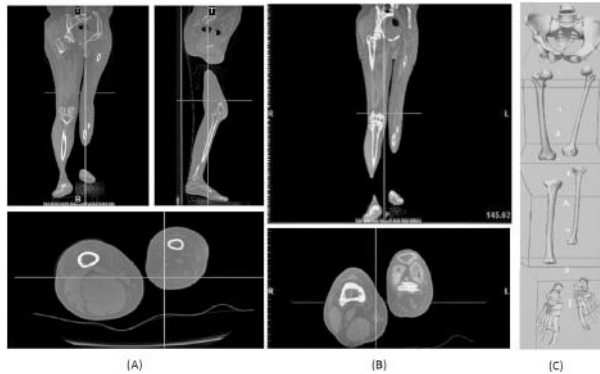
a) CT-based anatomical images, b) threshold-based segmented images and c) STL-based skeletal surface envelope model of the lower limb structures of a PPRP patient*
